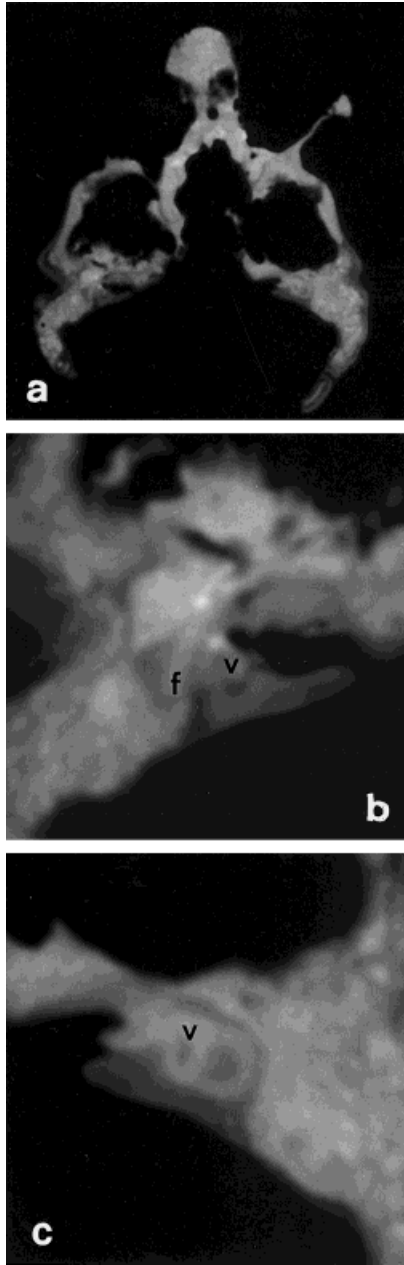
a: Transverse overview CT scan at the level indicated in Fig. 1. b,c: Zoom reconstruction of the right (b) and left (c) temporal bone areas, showing the vestibule (v) and the lateral semicircular canal of the normal labyrinth on the left and the irregularly shaped vestibule (v) as well as the intact second part of the facial canal (f) on the right side.
